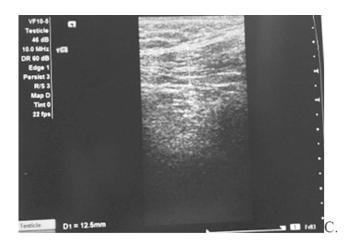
Pre-operative ultrasound findings of the inguinoscrotal mass.
